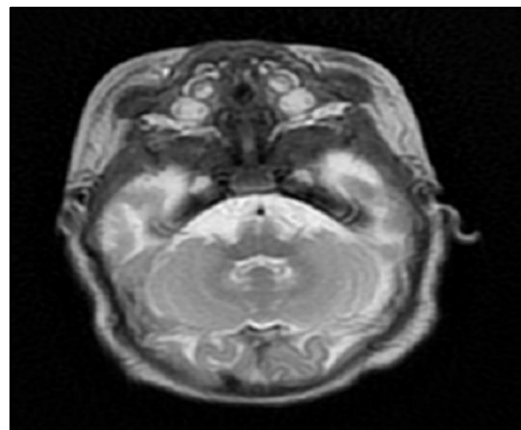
MRI showing palatal defect.
